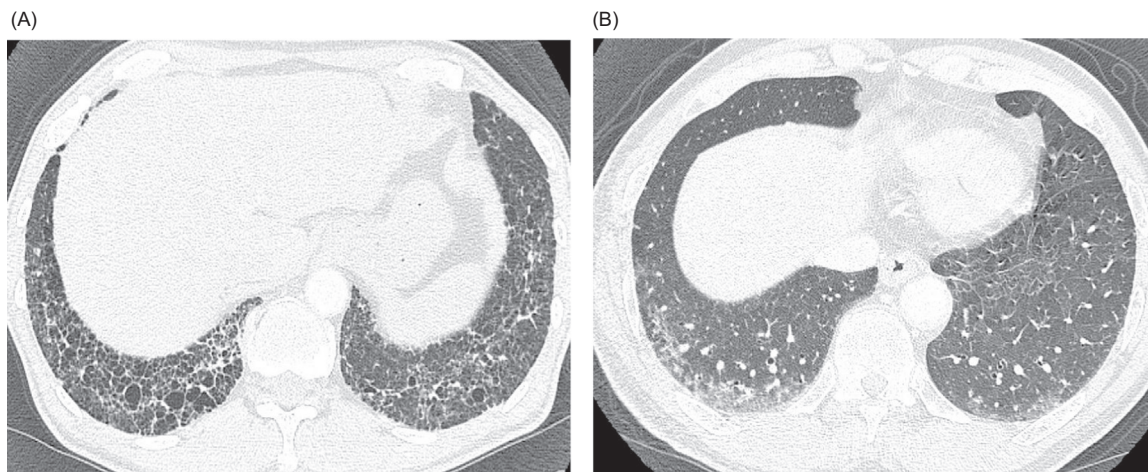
The diagnosis of ILD on chest CT was performed according to the criteria of an official ATS/ERS/JRS/ALAT statement. ILD was classified into, The figure 1A represents the usual interstitial pneumonia (UIP) pattern, while figure 1B represents the non-specific interstitial pneumonia (NSIP) pattern.
